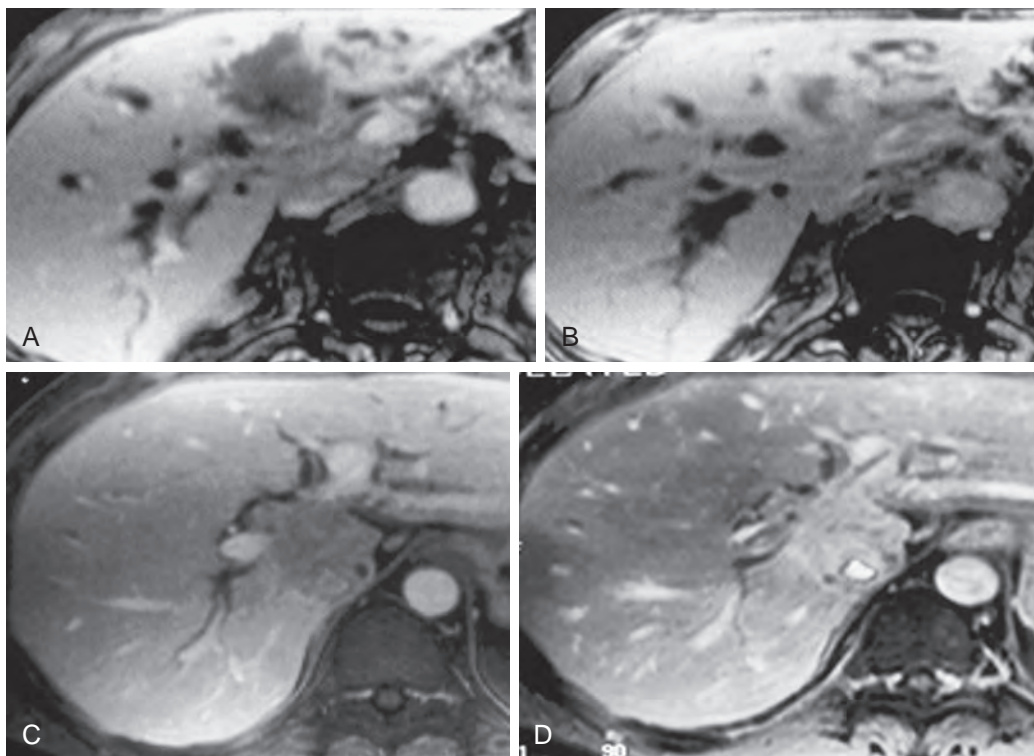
ICAC: MRI findings. No significant enhancement of the tumor is noted on the early phase scan (A), but on the 10-minute delayed scan (B), there is enhancement with the exception of the central scar. In a different patient, the lesion in the caudate lobe does not enhance on early scan (C) but does on delayed scan (D).
